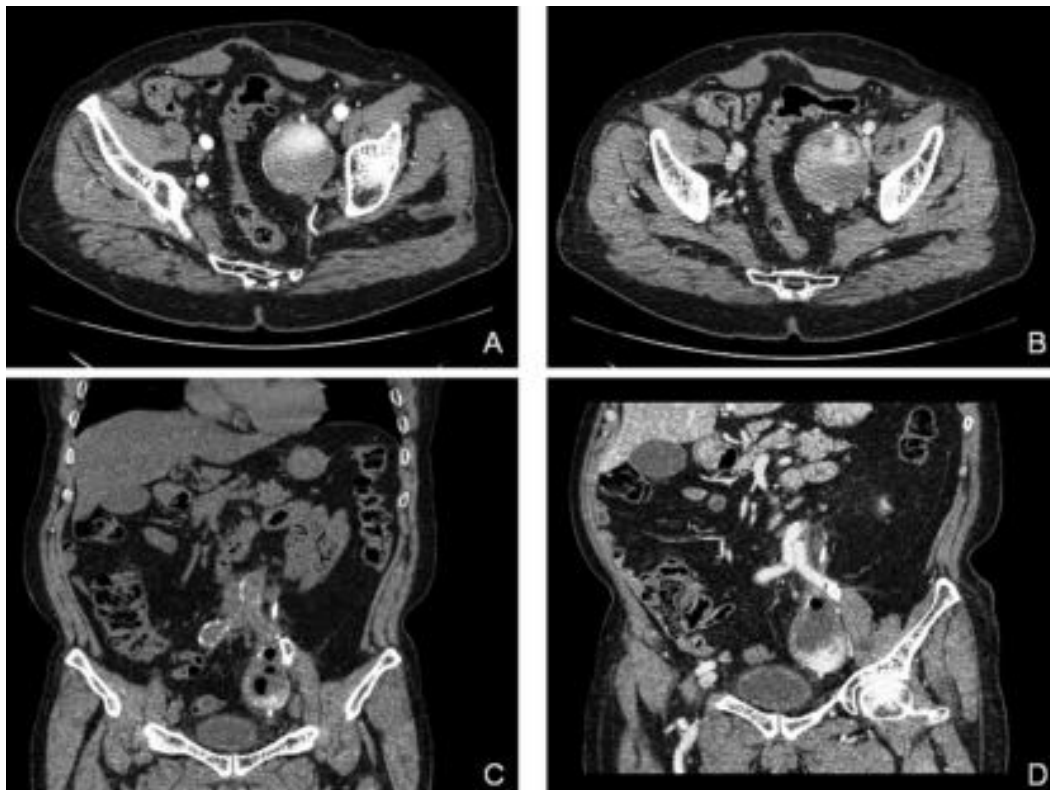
Axial and coronal post-contrast CT images, in arterial phase (A,C) and tardive phase (B,D). The dynamic study after i.v. administration of contrast medium shows that the contents of the aneurysm do not change in the different phases. There is no active blood supply and the aneurysm is excluded from the vascular system by the iliac stent.
